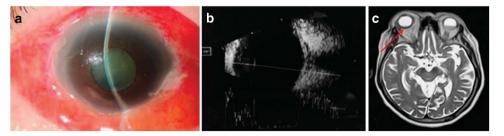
Findings at initial presentation. (a) Slit-lamp photograph of the right eye showing chemosis and conjunctival injection, corneal edema, and flat anterior chamber with fibrin pupillary plaque. (b) B-scan ultrasonography of the right eye showing clear vitreous and 'T-sign' without retinal detachment. (c) MRI of orbits and brain showing orbital inflammation, scleral enhancement, and optic nerve enhancement (red arrow), with no ciliary body, choroidal, or intracranial abscesses.
